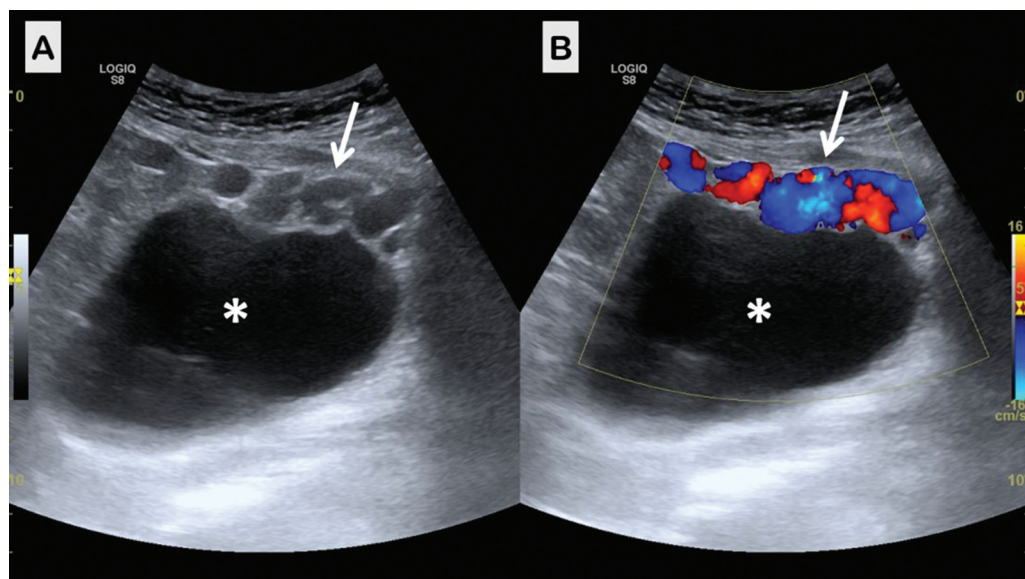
Transabdominal grayscale ultrasound (A) and adjoining Doppler image (B) showing multiple vascular channels (arrows) abutting the anterior wall of the urinary bladder (asterisks).
